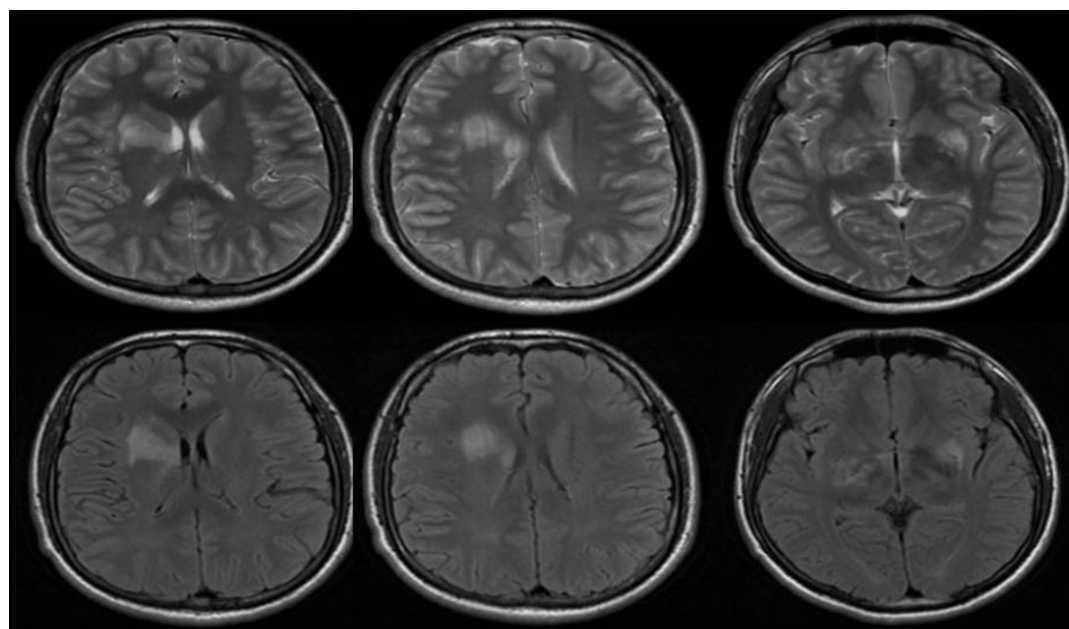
Abnormal signal can be seen in bilateral hippocampus and right putamen in the brain magnetic resonance imaging, shows high signal on T2WI and high signal on Flair
